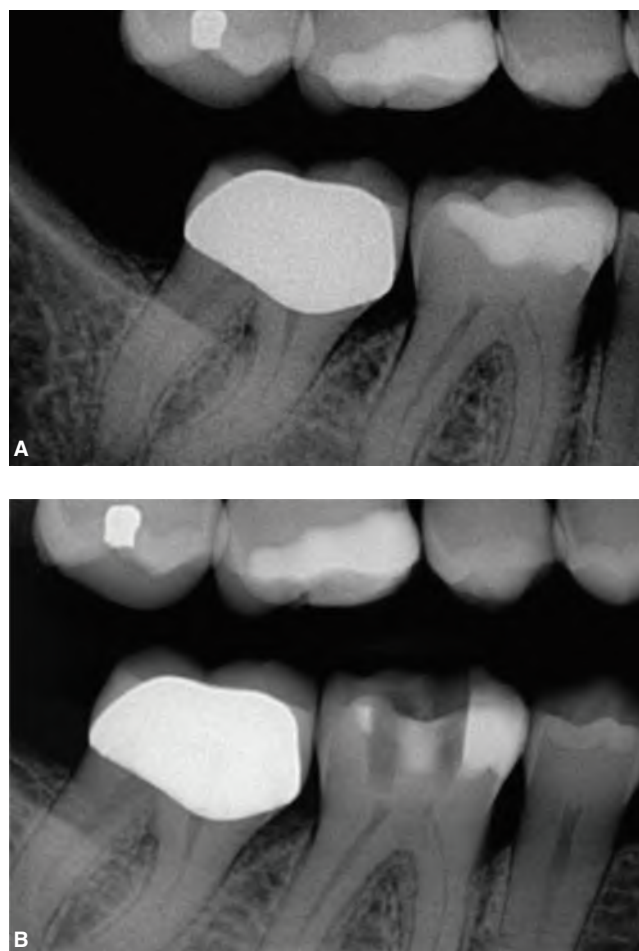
Access preparation assessment prior to placement of the dental dam in a 69-year-old patient. A. Preoperative bitewing radiograph of the mandibular right first molar. The pulp chamber appeared partially obliterated. B. Intraoperative bitewing radiograph taken without the dental dam for orientation purposes.
